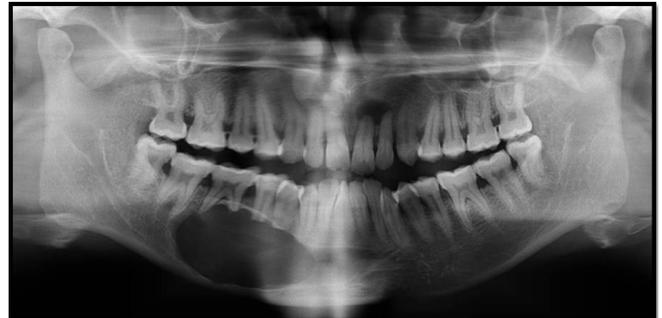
(c): Panoramic radiograph shows well defined unilocular radiolucency extending from 43 region to 46 region surrounded by corticated borders. Root resorption evident w.r.t 43, 44, 45, 46.
